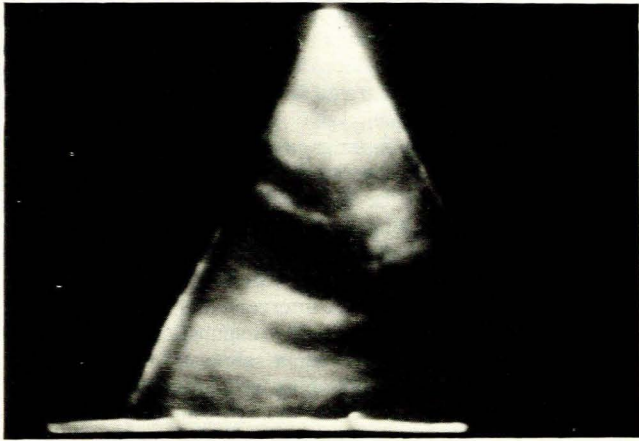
Postoperative two-dimensional echocardiogram. Fistula no longer visualized.
